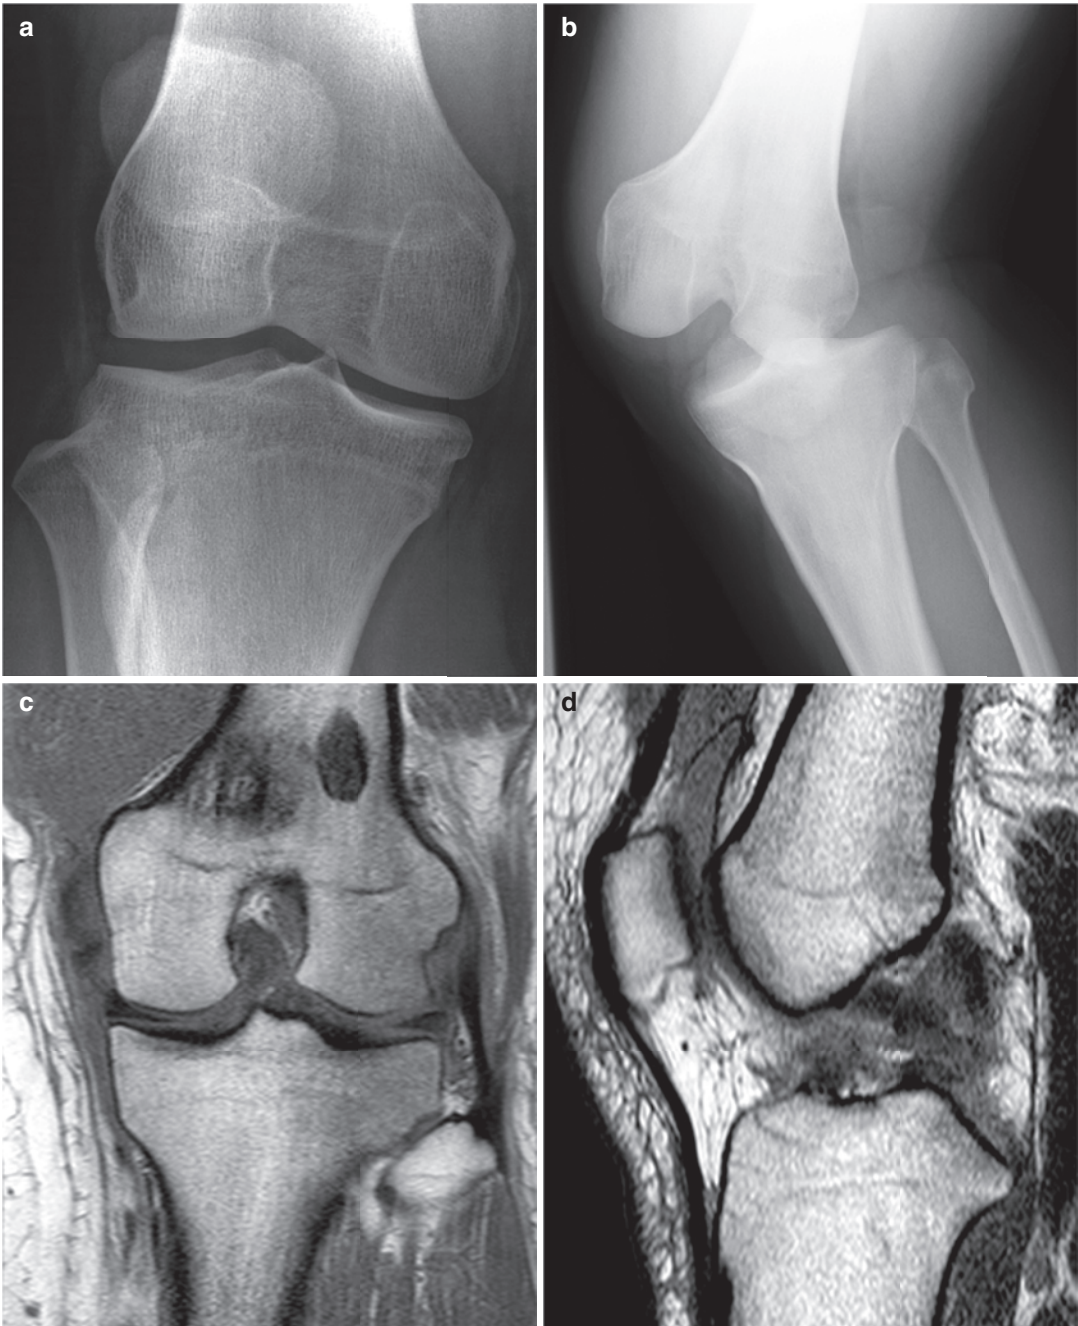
(a) Osteophyte formation within the medial tibia of the right knee, (b) left knee dislocation indicated on radiography, (c) MCL rupture shown on MRI, (d) ACL and PCL ruptures shown on MRI, (e) ACL and PCL
